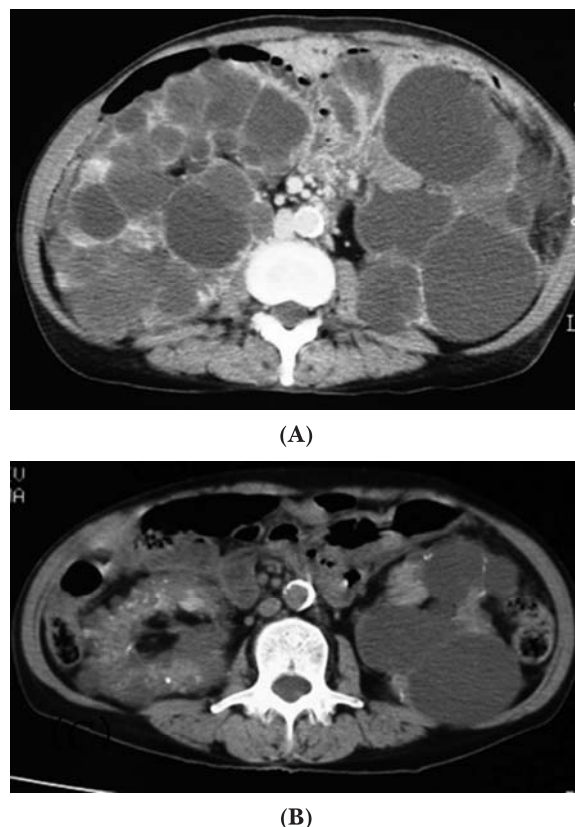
(A) CT images before embolization shows markedly enlarged bilateral kidneys with multiple cysts. (B) At 20 months after embolization, the size of both kidneys has decreased. However, renal cysts with moderate size still remain in the left kidney.
